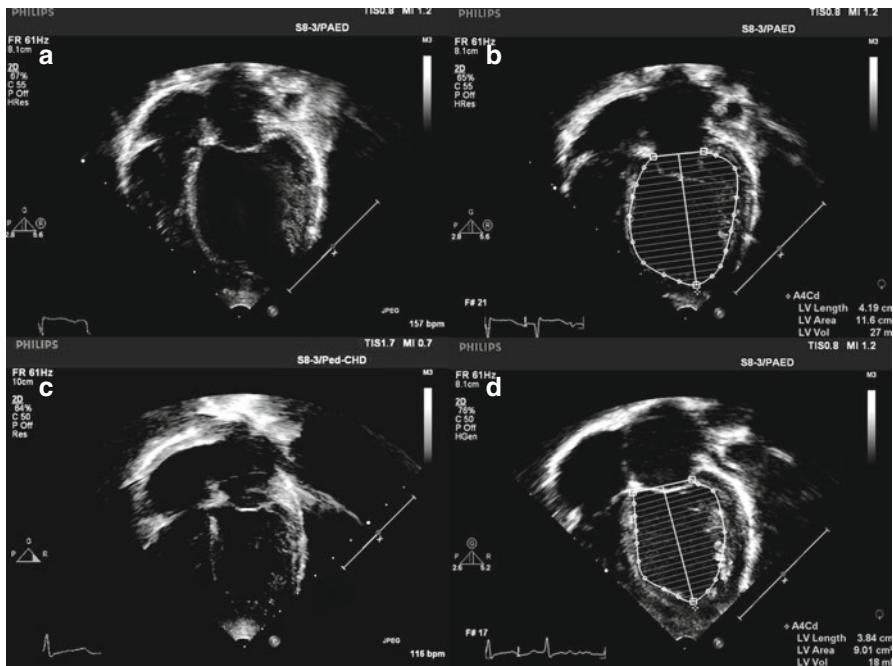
(a) Apical four-chamber view at presentation showed a dilated left ventricle with impaired systolic function and (b) Simpson's biplane calculation showing estimated LV diastolic volume of 27 mls (90 mls/m²). (c) Apical four-chamber view 10 months after presentation showing a reduction in LV volume and improved systolic function and (d) Simpson's biplane calculation showing estimated LV diastolic volume of 18 mls (60 mls/m²)
